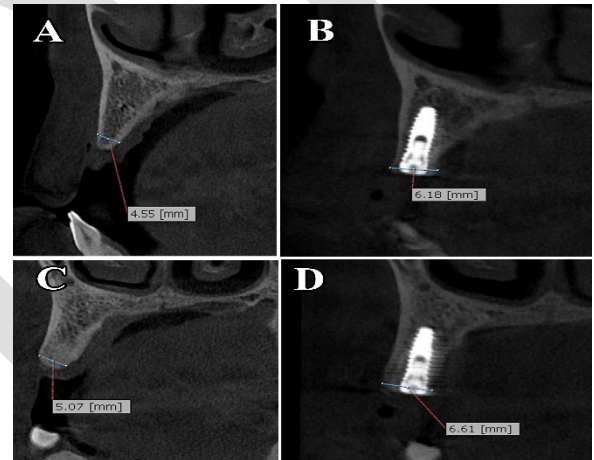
showing radiographic assessment for bone width gain
